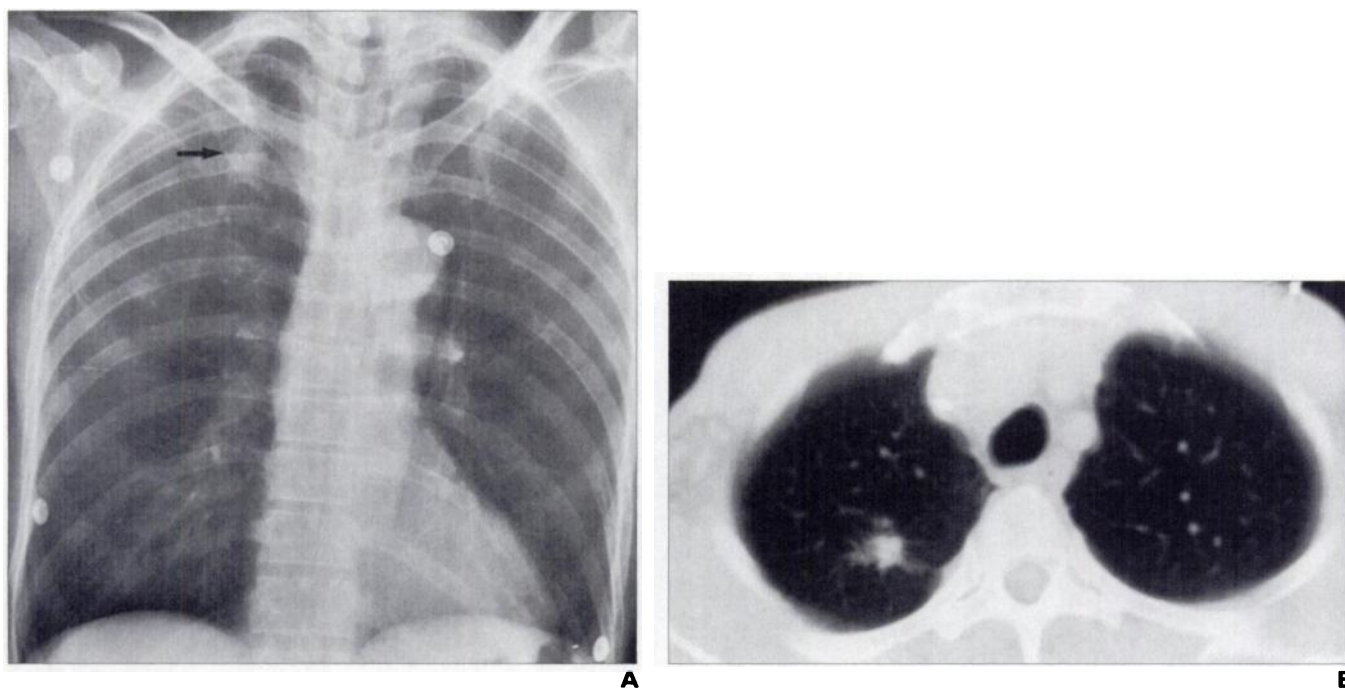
53-year-old man with primary lung carcinoma evident on CT who had chest radiograph originally read as negative. In retrospect, lesion is visible.
